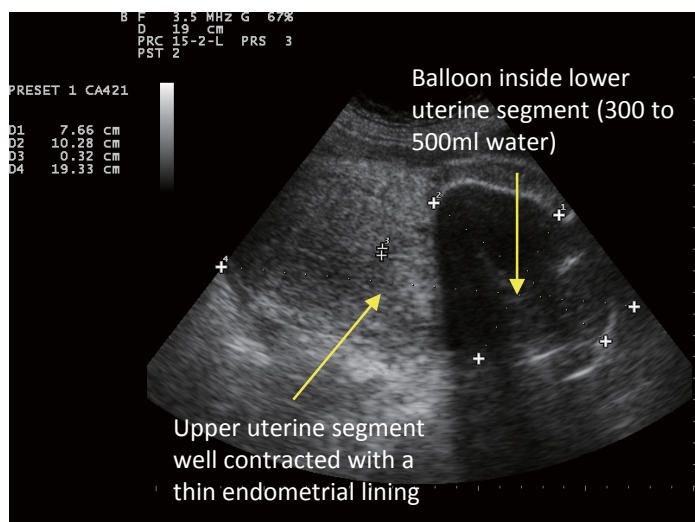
Ultrasound (transabdominal) assessment post-balloon tamponade showing the signs of success
